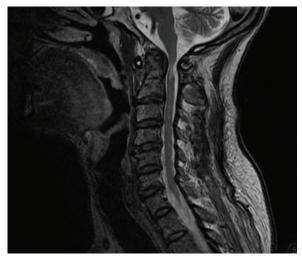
Preoperative sagittal cervical spine magnetic resonance image in a 54-year-old man with cervical myelopathy and atlantoaxial instability.
